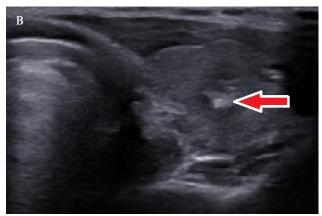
Patient 1. Ultrasonography of the thyroid gland; advanced medullary thyroid carcinoma in each lobe of the thyroid gland with calcifications (A,B).
